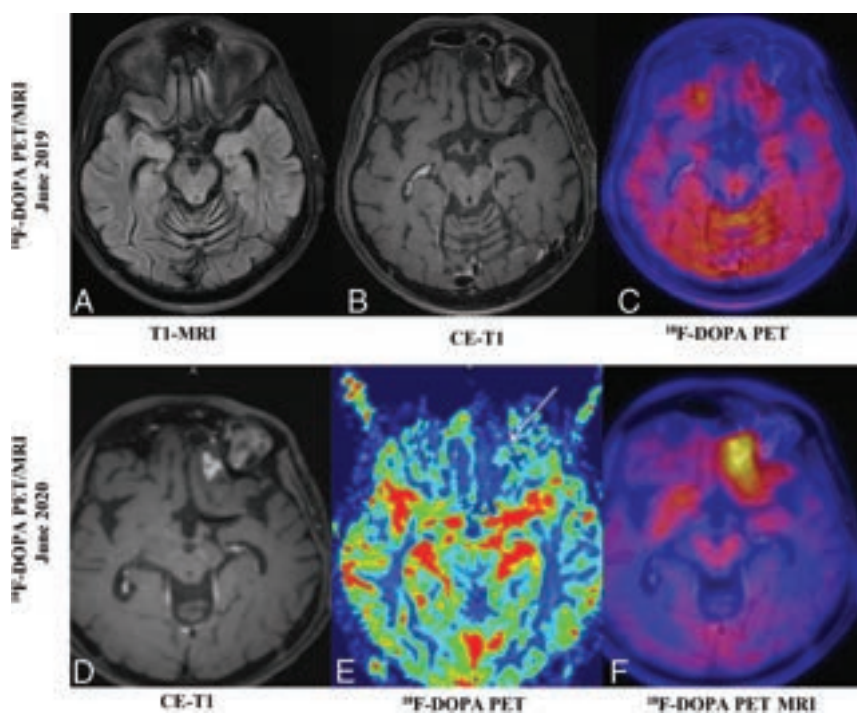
A 35-year-old man was treated for left frontal glioma (grade II), status post surgical resection and chemoradiation in 2009. He underwent a reoperation in February 2018 for tumor recurrence. In June 2019, [¹⁸F] DOPA PET MR imaging (A–C) showed a postresection surgical cavity in the left anterior parasagittal basifrontal region without nodular enhancement or any increased focal FDOPA uptake. There was no evidence of recurrence. In June 2020, follow-up [¹⁸F]-DOPA PET MR imaging (D and E) showed a new focal nodular enhancing lesion in the left basifrontal area (arrow) on the postcontrast T1-weighted image (D), with mildly increased rCBV perfusion (E) and corresponding increased FDOPA uptake on fused FET-PET MR imaging (F) (maximum standard uptake value = 3.9; lesion/striatal ratio; 1.38; <1.0 as normal), suggesting recurrence. The patient underwent a reoperation with recurrence found. This case also highlights the congruent findings on contrast-enhanced MR imaging and FDOPA-PET in differentiating TRC from recurrence. CE indicates contrast-enhanced.
